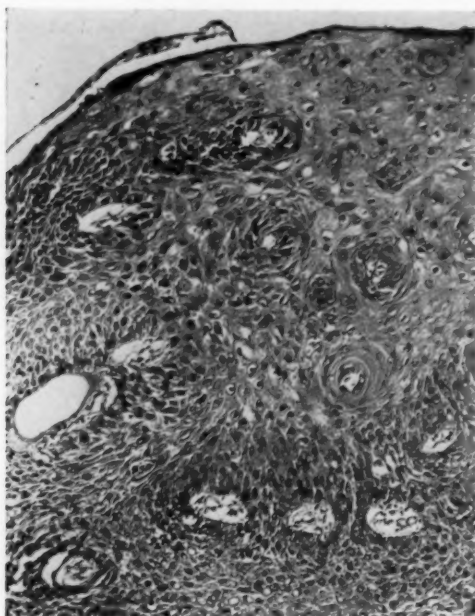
Case 2. July 17, 1952. Biopsy of right vocal cord interpreted as indication keratosis and no carcinoma. Cords then stripped of keratosis (July 21, 1952). Patient subjected to repeated biopsies and X-ray therapy to larynx. In 1957 biopsy showed carcinoma, and laryngectomy was done.
